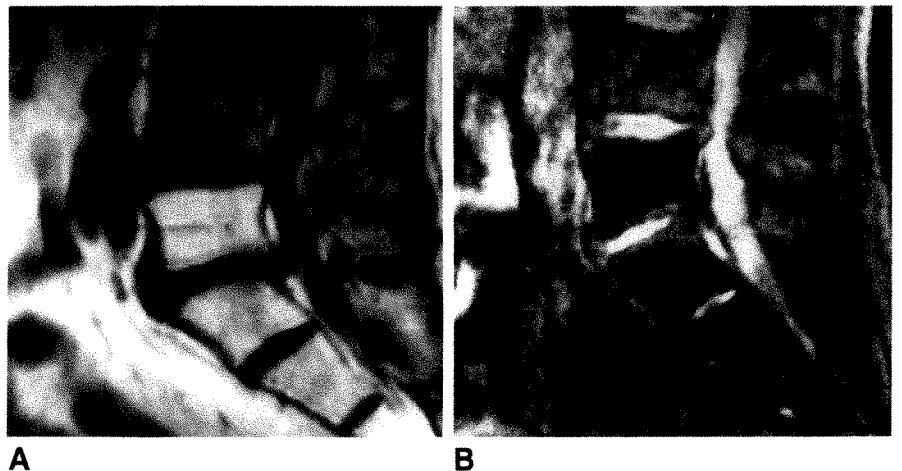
A and B, T1-weighted, 300/30 (A), and STIR, 1500/100/30 (B), images of lower lumbar spine in 70-year-old patient with prostate carcinoma 46 days after initiating a 6-week course of 5000 rad (50 Gy). Diffusely homogeneous bright signal intensity on T1-weighted image corresponds to identical region of decreased signal intensity on STIR image.
